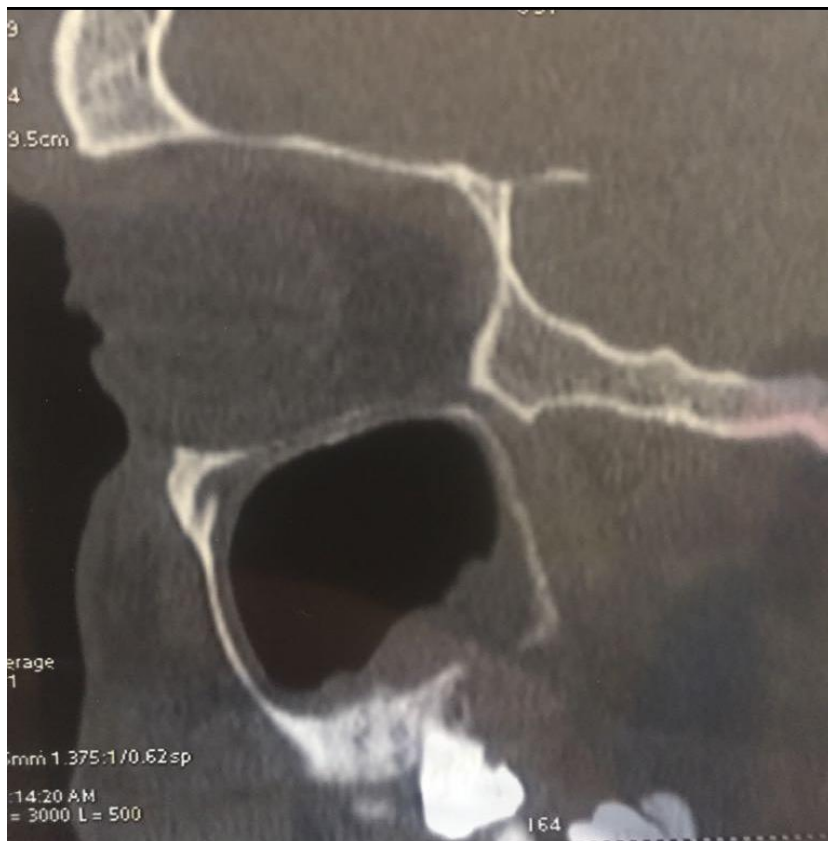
Computed tomogram of patient S; before surgery: the defect of the alveolar process of the right upper jaw, the fistula of the right maxillary sinus with the oral cavity, and thickening of the sinus mucosa are visualised
